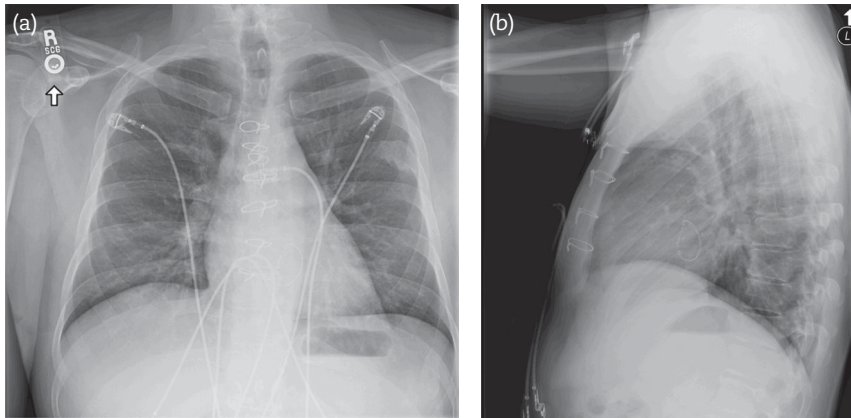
Chest radiograph of patient on presentation.
